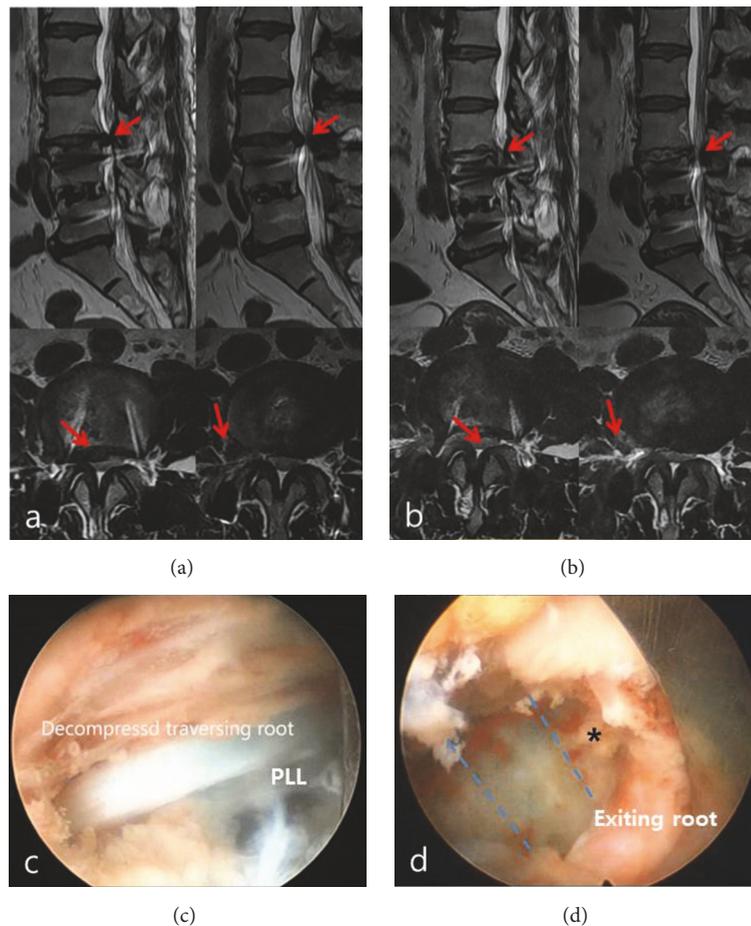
Single level multi-focal, paracentral, and far-lateral lumbar disc herniations. (a) Preoperative sagittal and axial T2-weight MRI showing multifocal, paracentral, and far-lateral lumbar disc herniations at L3-4. Red arrows: paracentral and extraforaminal disc herniation. (b) Postoperative axial and sagittal T2-weight MRI showing the removed paracentral and far-lateral lumbar disc herniations at L3-4. Red arrows: decompressed area by removal of paracentral and extraforaminal disc herniation. (c) Paracentrally herniated disc materials were removed and decompressed traversing root was seen. PLL: posterior longitudinal ligament. (d) Change of working cannula angle showing the foraminal area. Asterisk: tip of remnant extraforaminal disc; dotted blue line: disc level.
